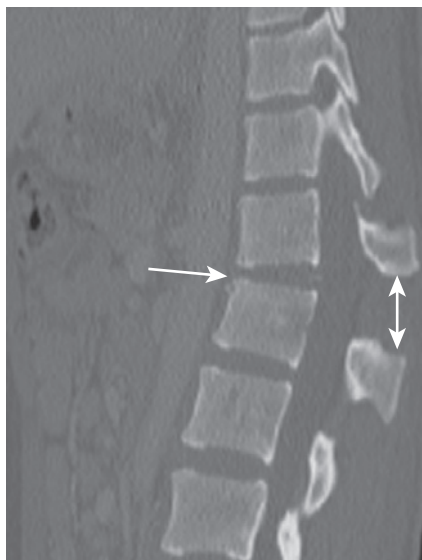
Sagittal computed tomography of the thoracolumbar spine demonstrating a flexion-distraction injury extending horizontally through the superior aspect of T12 with widening of the intervertebral disc space and increased distance between the spinous processes due to discoligamentous disruption.
